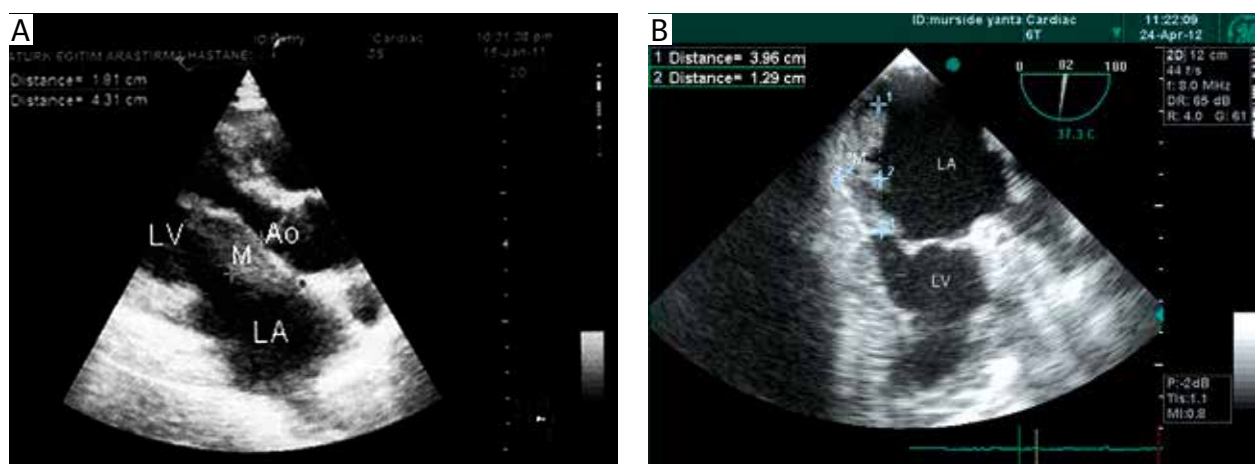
A) Preoperative ECHO revealed a large tissue mass in the left atrium. B) TEE (transoesophageal echocardiography) test showing recurrence of the mass lesion in the left atrium
